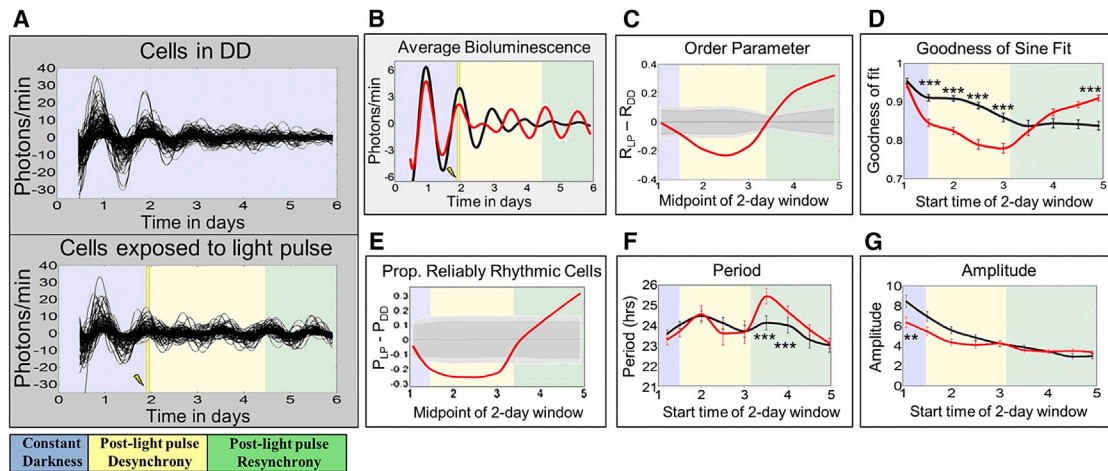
Oscillators in Constant Darkness Demonstrate Gradual Desynchrony Over Time, Whereas Oscillators Exposed to a White Light Pulse at CT 22 Show Synchrony Phase Retuning
